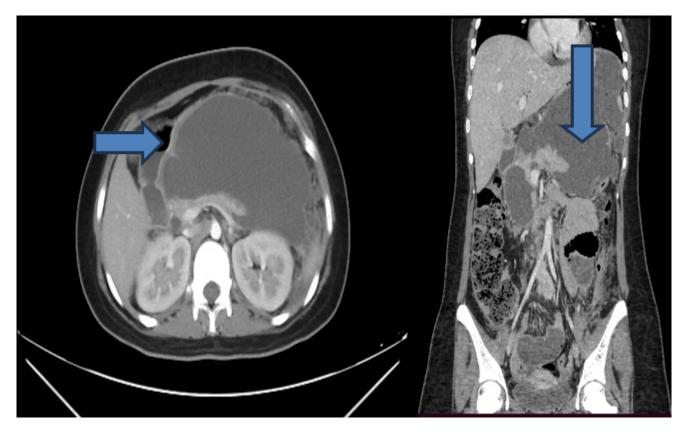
Abdominal CT scan showing acute pancreatitis with ascites
